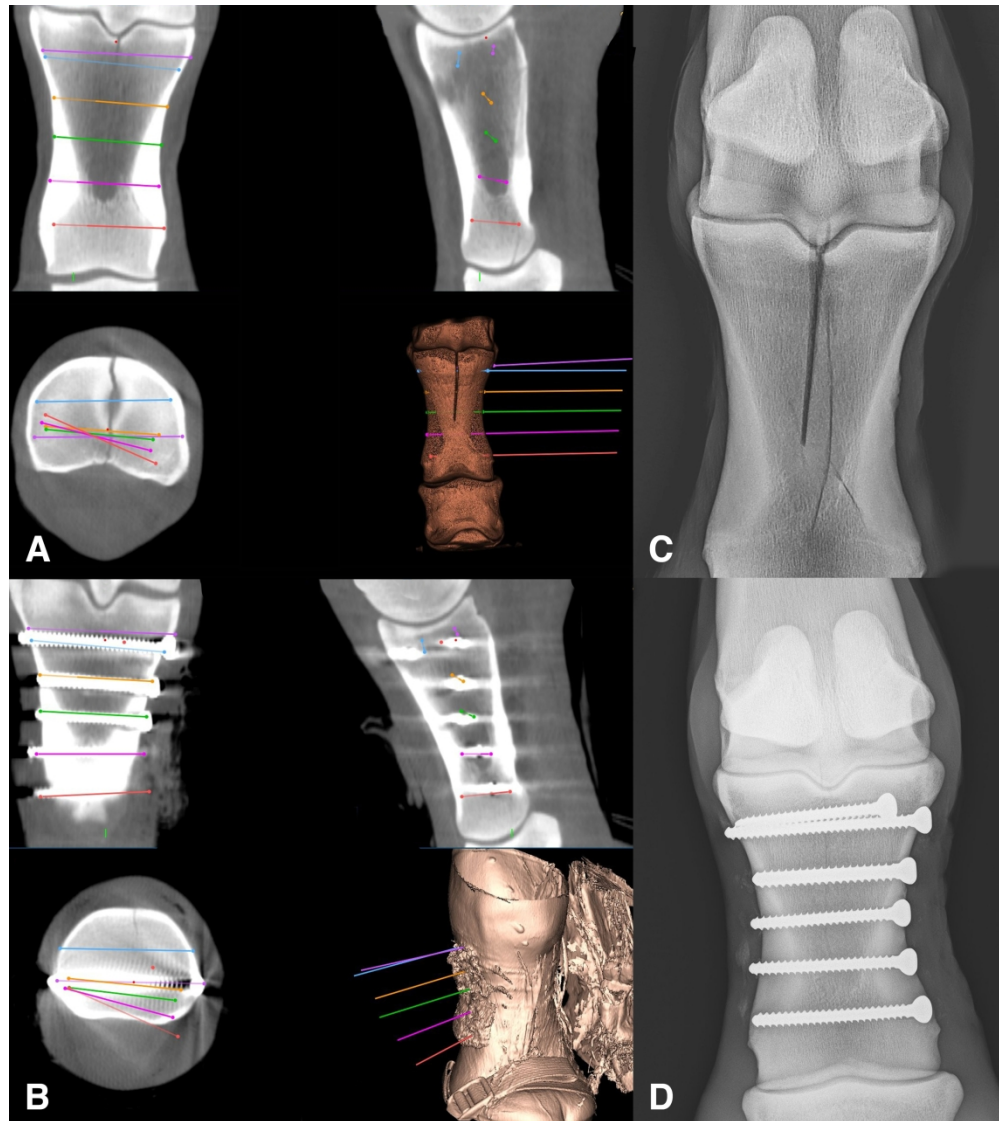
Screen shots of the Cranial Software (Medtronic) displaying (A) the preoperative plan for the repair of a complete bi-articular proximal phalanx fracture (case 8). Each colored line represents the planned core axis of a screw implant. (B) Merged pre- and postoperative cone beam computed tomography scans including the placed implants. The fracture is well reduced despite the most dorsoproximal screw being positioned slightly off plan (blue line). Also, note the beam-hardening artefact caused by the metallic implants and the strap and buckle of the purpose-built frame in the volumetric reconstruction, bottom right. (C) Pre- and (D) postoperative dorsopalmar radiographs.
